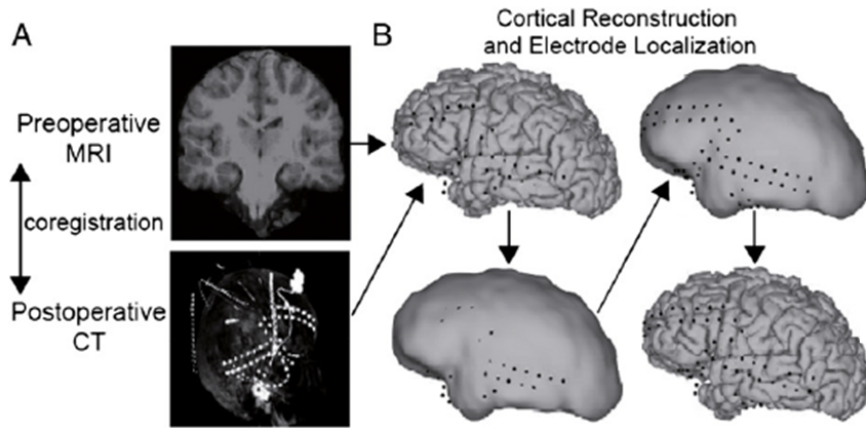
Outline of electrode localization procedure. (A): The preoperative MRI is coregistered with the postoperative CT volume. The lower panel shows the maximal-intensity projection of the CT volume in the sagittal dimension, which shows all the contacts in a sagittal plane. (B): Due to the parenchymal shift from the implant procedure, some contacts initially appear buried in the gray matter (left panel). To correct for this, each contact coordinate is projected first to the smoothed pial surface and subsequently back to the pial surface (right panel). Courtesy of [9].
